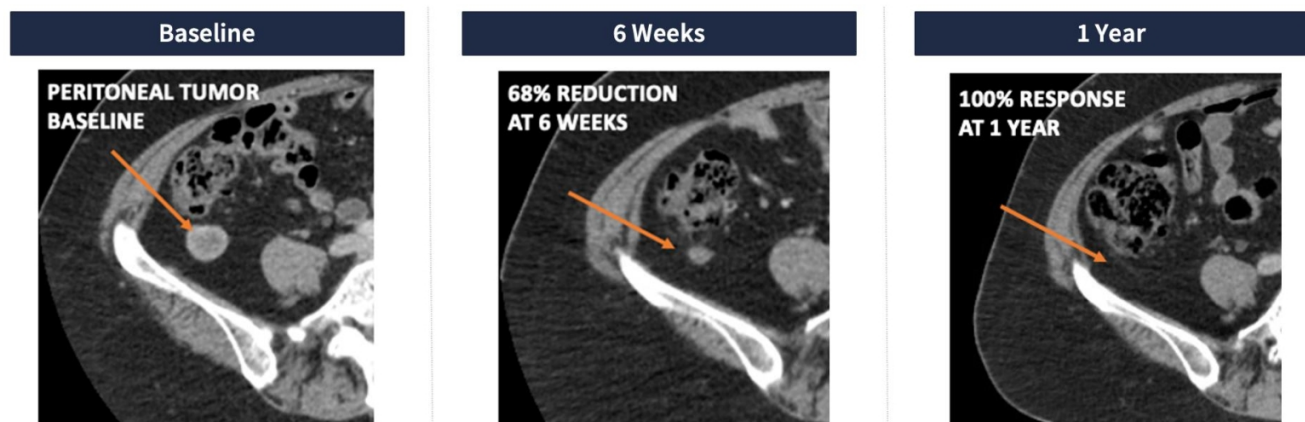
Durable radiographic response following treatment with ENB-003 and pembrolizumab in a patient with MSS, platinum-refractory, PD-L1-negative ovarian cancer. A large tumor decreased by 68% after six weeks, was undetectable at 12 weeks and remained undetectable at 12 months. Overall, the patient had a 95% partial response that was durable out to a year.
